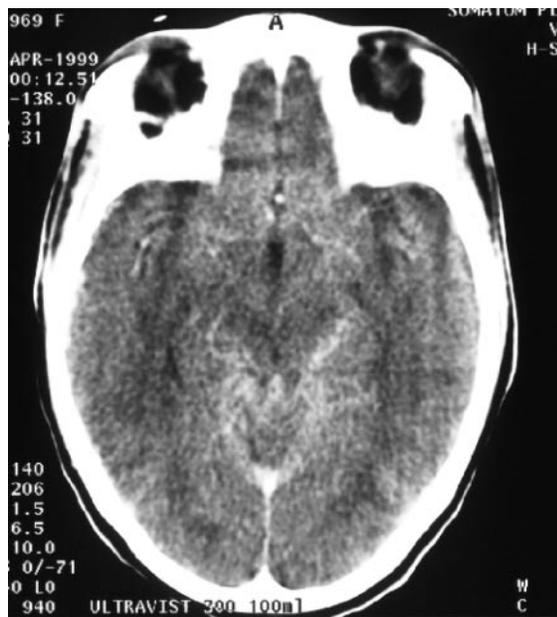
CT scan showing basal meningeal enhancement in a patient with presumed TB.
